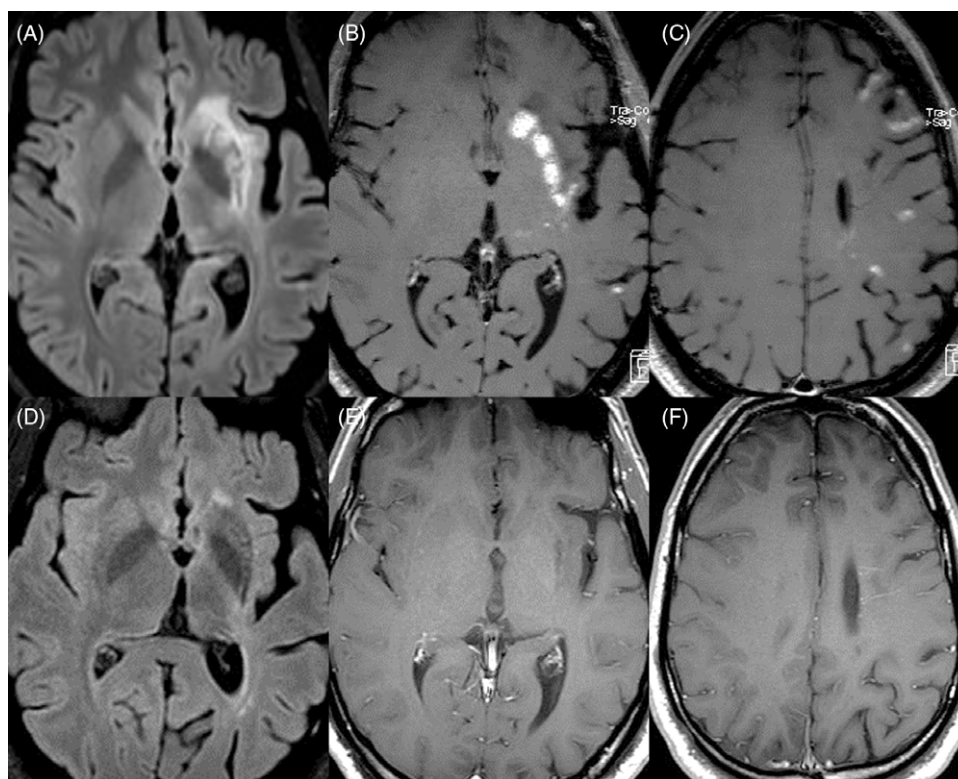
Neuroimaging improvement after immunotherapy for unilateral relapsing primary angiitis of the CNS. Brain MRI shows left-sided striatal T2-FLAIR-hyperintensity (A) and gadolinium enhancement (B); left-sided gadolinium-enhancing cortical/juxta-cortical lesions are also seen (C). Mild left-hemispheric atrophy is present (A–C). Follow-up MRI 11 months post-immunotherapy shows marked improvement of T2-FLAIR-hyperintensity (D) and enhancement (E, F).
